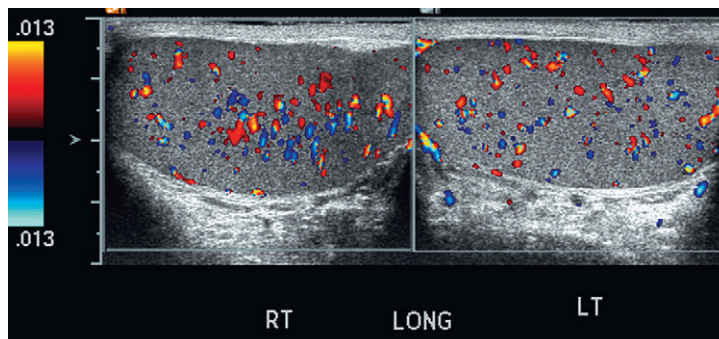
Longitudinal Doppler ultrasound image of both testicles using a split screen format. Note the symmetry of echotexture and the uniformity and symmetry of colour flow.
